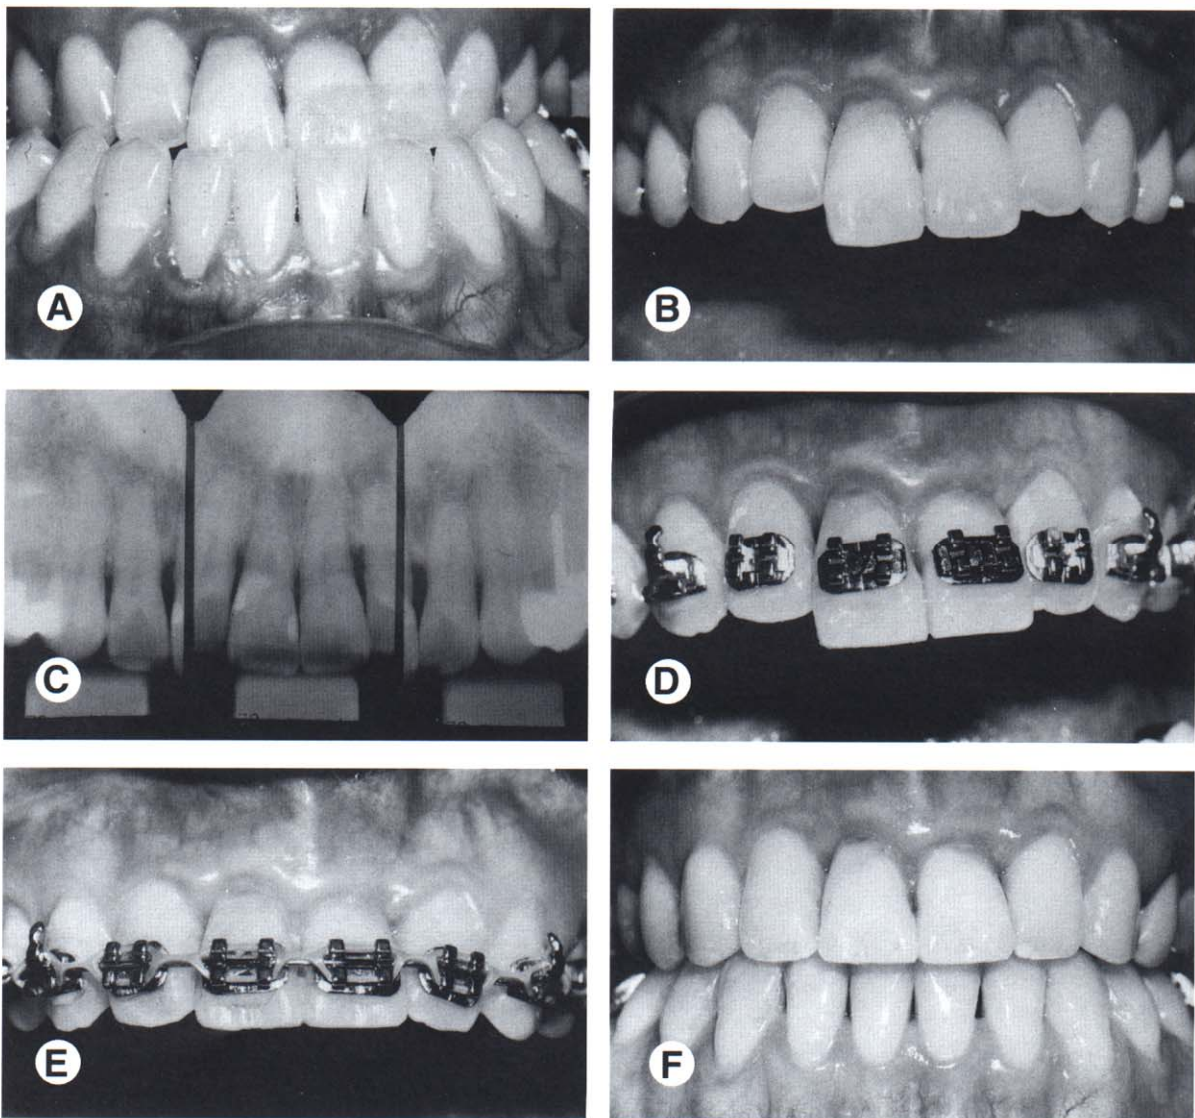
Before orthodontic treatment, this patient had a significant Class III malocclusion (A). The maxillary central incisors had overerupted (B) relative to the occlusal plane. A pretreatment periapical radiograph (C) showed that significant horizontal bone loss had occurred. To avoid creating a vertical periodontal defect by intruding the central incisors, the brackets were placed to maintain the bone height (D). The incisal edges of the centrals were equilibrated (E) and the orthodontic treatment was completed without intruding the incisors (F).
